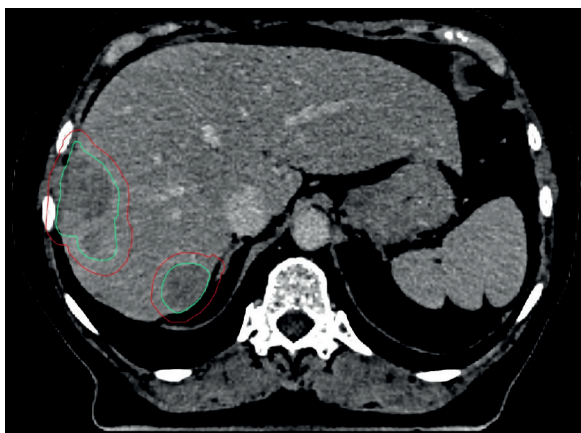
A: CT showing delineation of the lesion in the liver; green – gross tumor volume; red – planning target volume; B: SBRT with 50 Gy in 5 fractions
